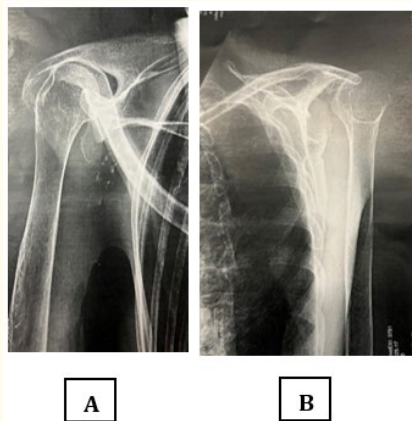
X-rays of posterior shoulder dislocation.
